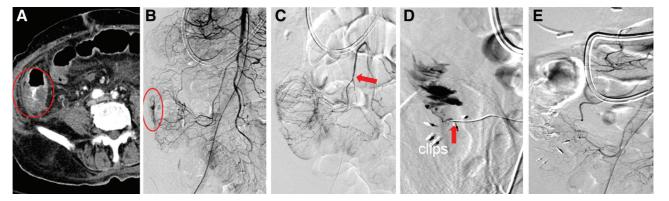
A 78-y-old end-stage renal disease male patient with duodenal bleeding and hypovolemic shock. He was complicated with respiratory failure and transferred to our hospital. During the admission, bloody stool for days was noted. A, Multidetector computed tomography demonstrated contrast extravasation in the ascending colon (circle). B, Superior mesenteric artery angiogram showed active bleeding in the ascending colon (circle). C, The tip of a microcatheter (arrow) was at the distal first branch of the right colic artery, which was too proximal for effective vasospastic therapy under the recommended dosage. The patient then underwent colonoscopic hemostasis as bleeding continued. D, Superselective angiogram showed recurrent bleeding after clips hemostasis. Arrow: microcatheter tip in the vasa rectum. E, Embolization was performed with NBCA injection into the vasa rectum with successful hemostasis. Unfortunately, this patient expired 8 d after NBCA embolization due to pneumonia with respiratory failure.
